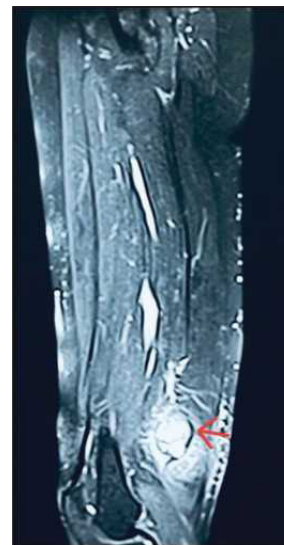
CE MRI of right thigh showing a soft tissue mass of $9.5 \times 4.5 \times 3.5$ cm (red arrow).
